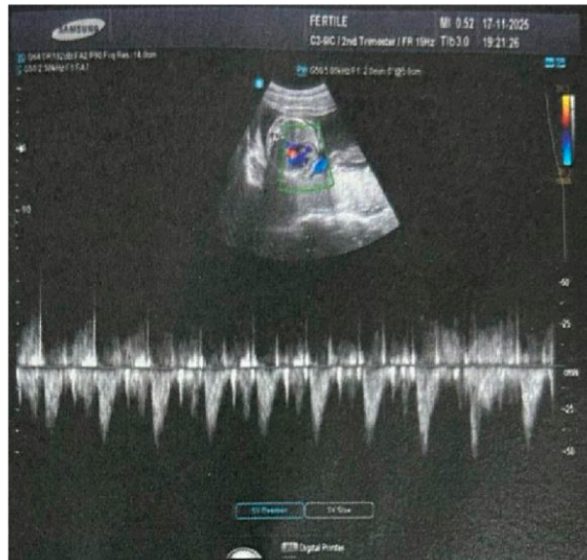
Obstetric ultrasound with Doppler at 23 weeks.
